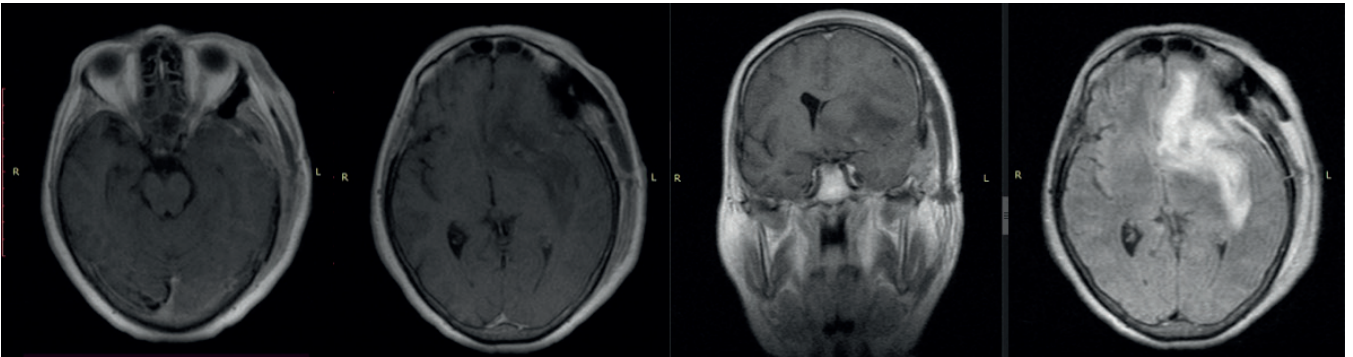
Two days postoperative follow-up MRI revealed brain edema without residual mass.
